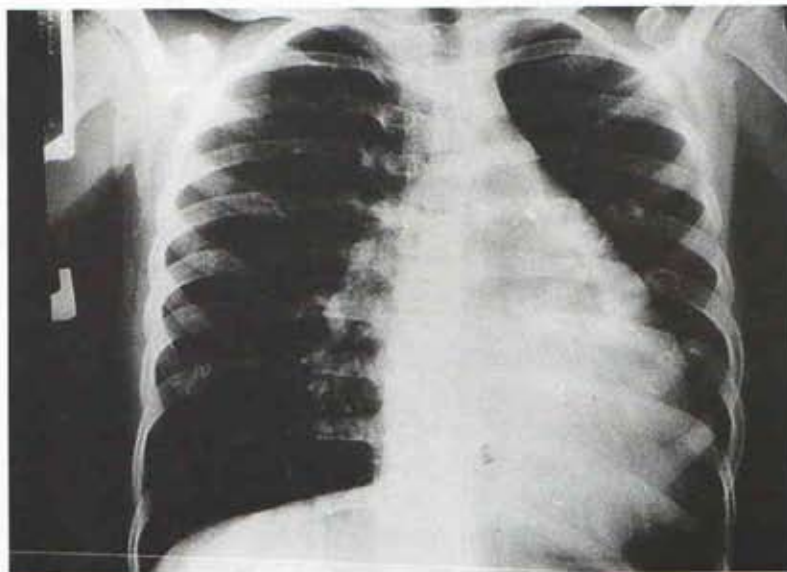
Preoperative chest x-ray of the patient with an radiopaque spider like apperance (umbrella).
